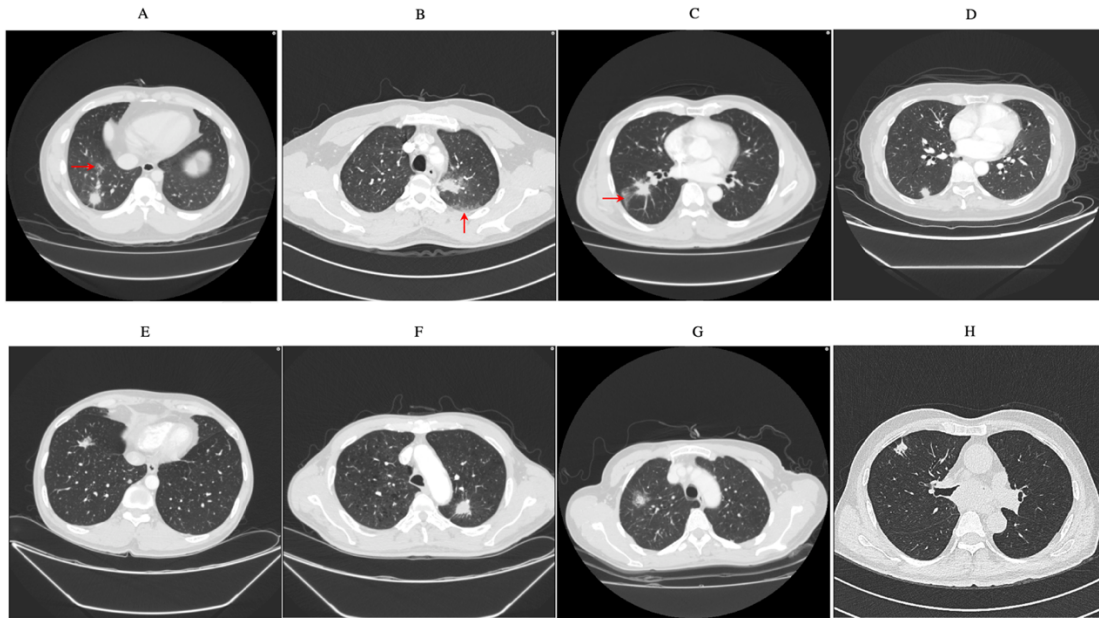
Several examples from the cohort. A-D: cryptococcosis nodule; E-H: malignant lung cancer nodules. The red arrows in A-C indicated possible other abnormal lung CT findings.
